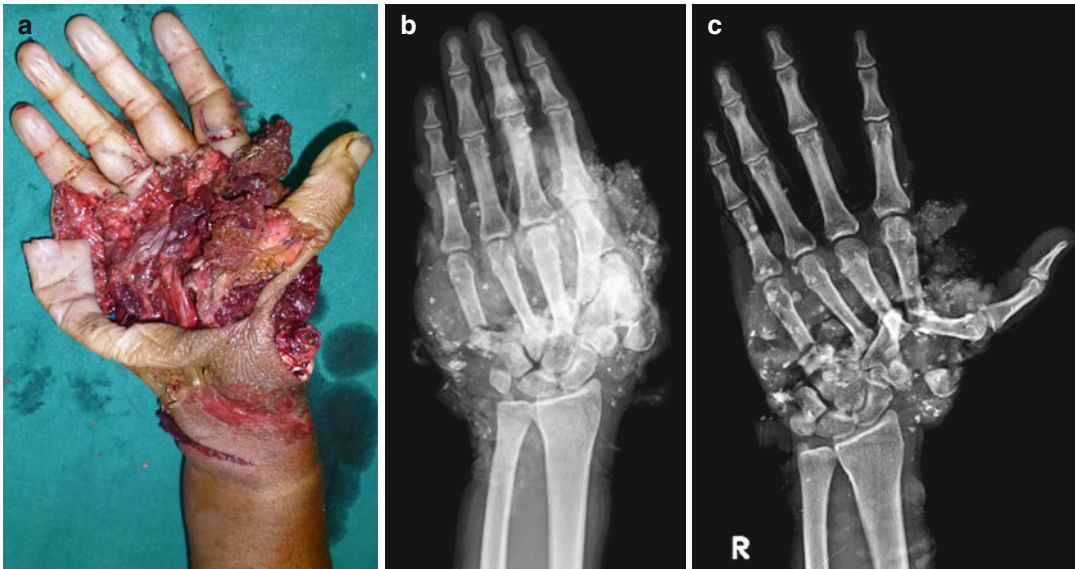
(a) A machine crush injury of the hand. (b) Radiograph taken on arrival with the bandage. (c) Radiograph taken after brachial block on arrival which shows the fractures more clearly
